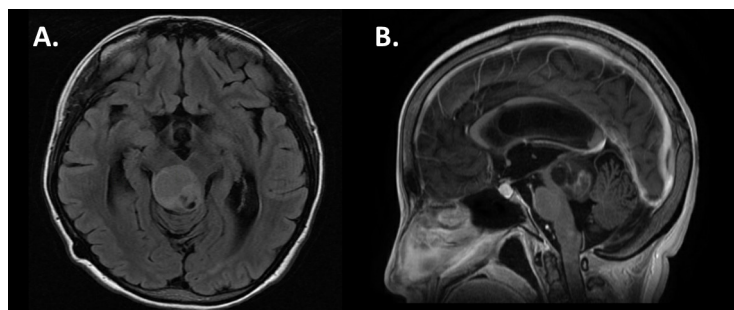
MRI demonstrates a cystic and solid hyperintense mass of the dorsal tectum (A) with associated minimal contrast enhancement and hydrocephalus (B).
